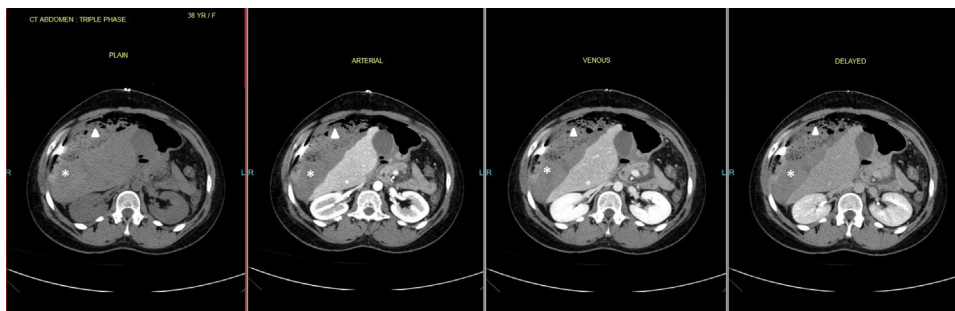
CT scan abdomen showing large sub-capsular hematoma.
